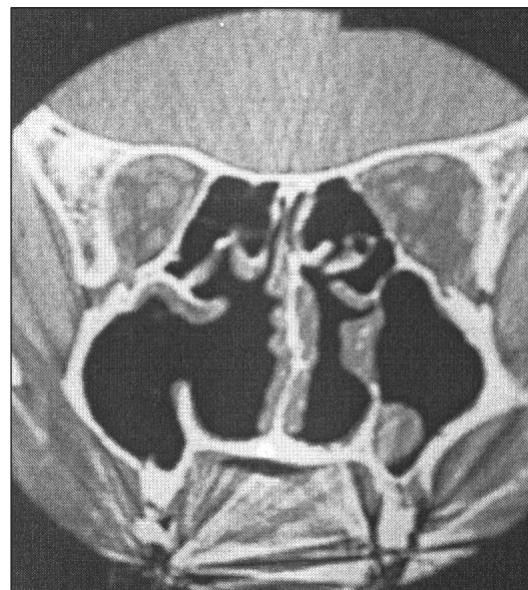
Coronal CT scan demonstrating widely patent nasal cavities, virtually absent turbinates and wide right ostium which is consistent with ENS.
